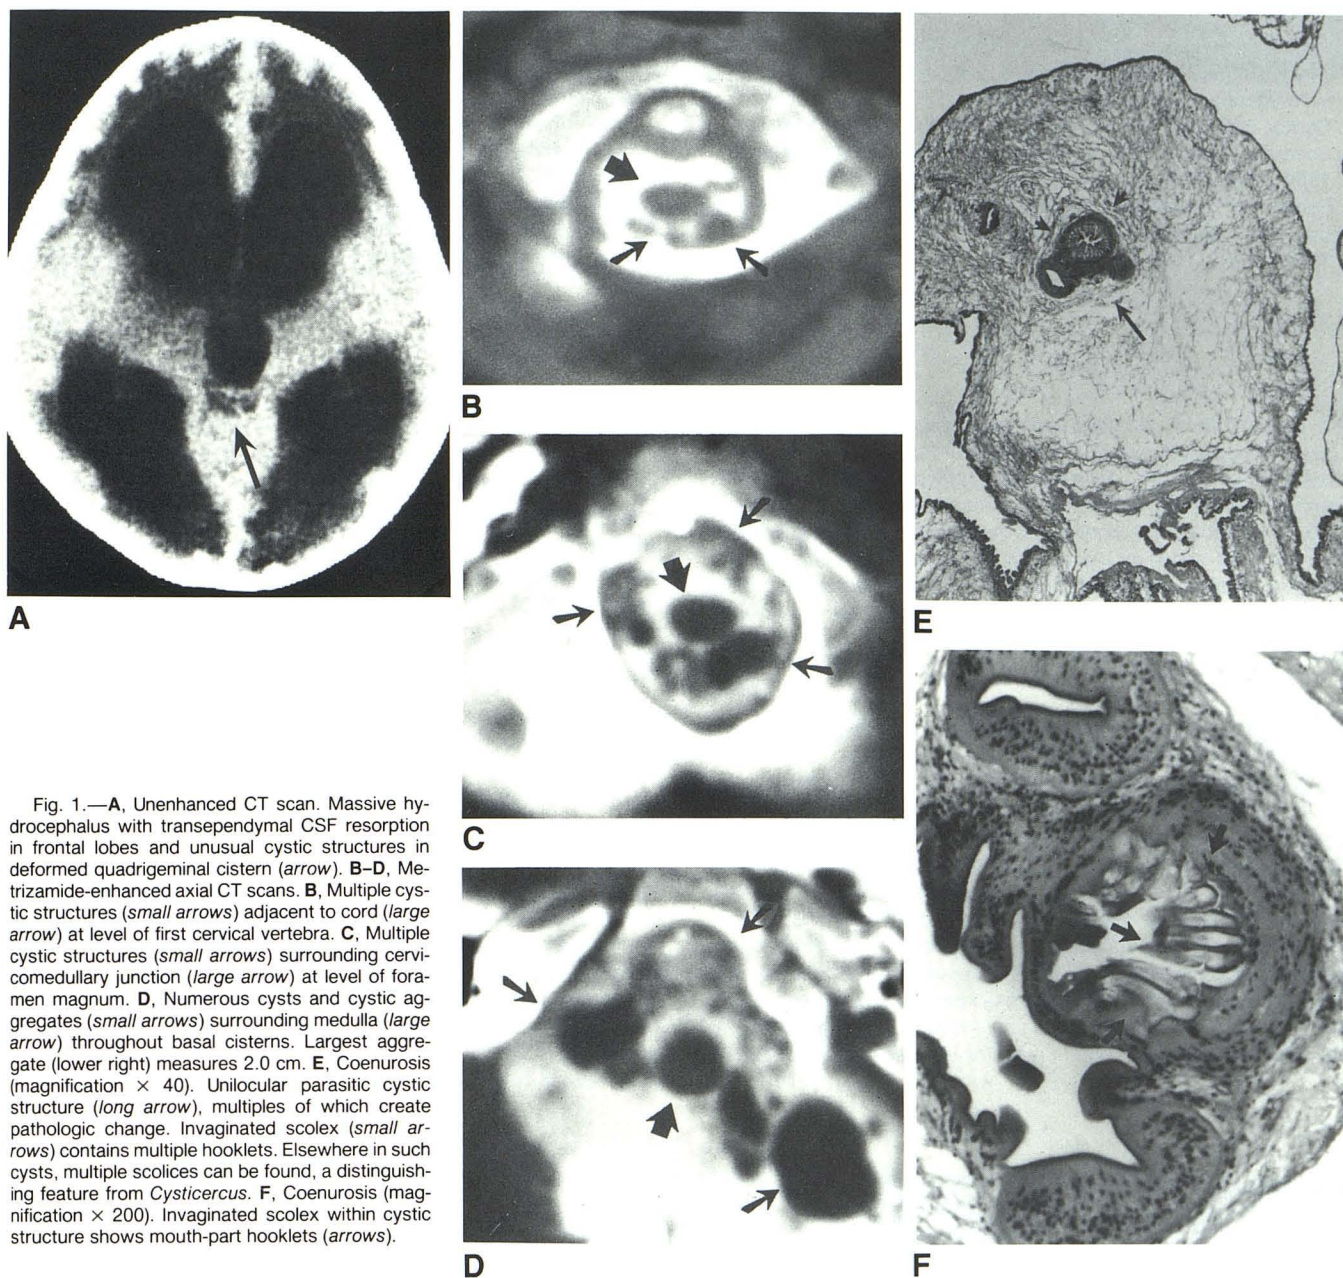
A, Unenhanced CT scan. Massive hydrocephalus with transependymal CSF resorption in frontal lobes and unusual cystic structures in deformed quadrigeminal cistern (arrow). B–D, Metrizamide-enhanced axial CT scans. B, Multiple cystic structures (small arrows) adjacent to cord (large arrow) at level of first cervical vertebra. C, Multiple cystic structures (small arrows) surrounding cervicomedullary junction (large arrow) at level of foramen magnum. D, Numerous cysts and cystic aggregates (small arrows) surrounding medulla (large arrow) throughout basal cisterns. Largest aggregate (lower right) measures 2.0 cm. E, Coenurosis (magnification $\times 40$). Unilocular parasitic cystic structure (long arrow), multiples of which create pathologic change. Invaginated scolex (small arrows) contains multiple hooklets. Elsewhere in such cysts, multiple scolices can be found, a distinguishing feature from *Cysticercus*. F, Coenurosis (magnification $\times 200$). Invaginated scolex within cystic structure shows mouth-part hooklets (arrows).
